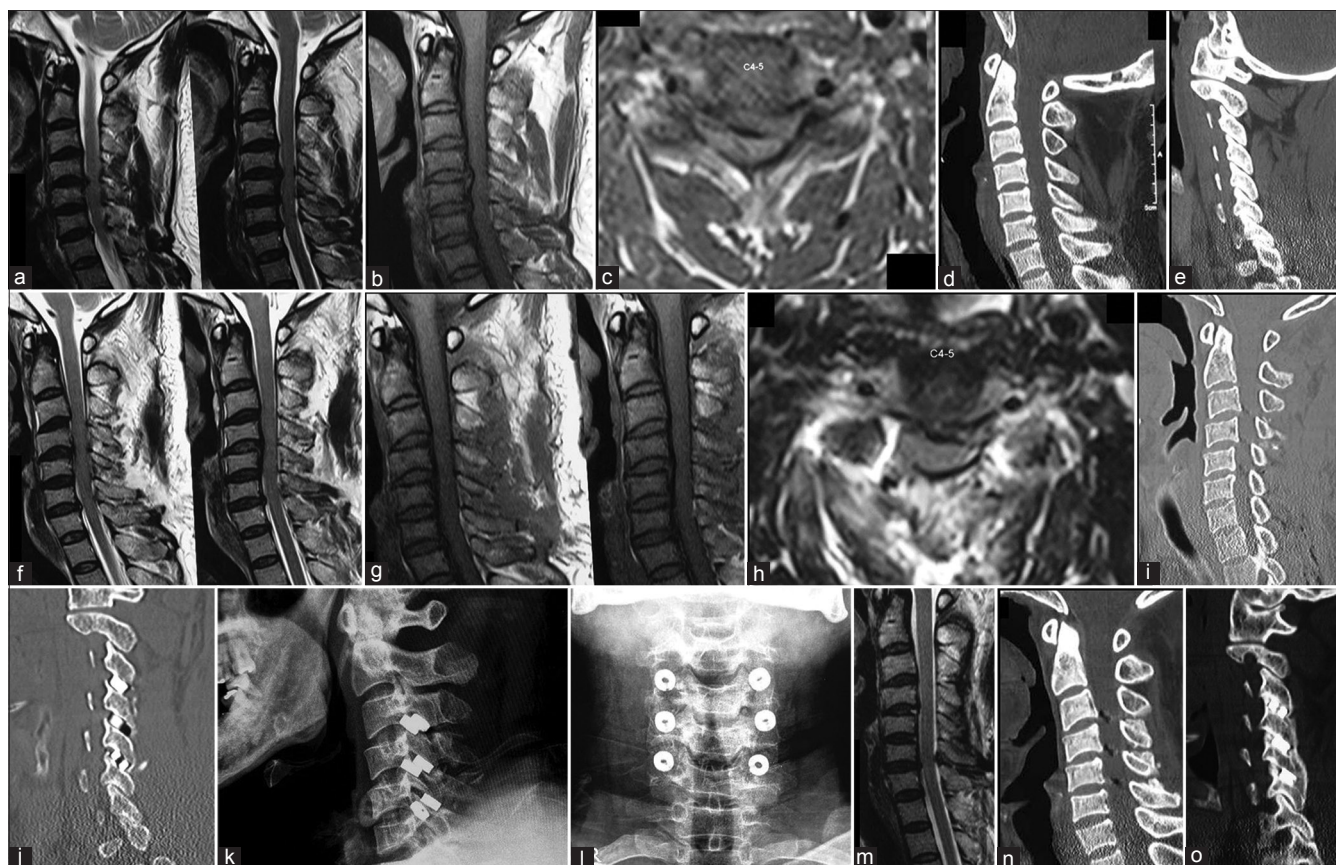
Images of a 45-year-old male patient. (a) Sagittal T2-weighted magnetic resonance imaging showing the C4-5 level disc protrusion. (b) Sagittal T1-weighted magnetic resonance imaging showing the herniated disc and an intact posterior longitudinal ligament. (c) Axial scan showing the herniated disc. (d) Preoperative computed tomography scan - sagittal image. (e) Preoperative computed tomography scan with sagittal cut passing through the facets. (f) Postoperative T2-weighted magnetic resonance imaging showing the restoration of the herniated disc and an increase in the disc space height. (g) T1-weighted magnetic resonance imaging showing the restoration of the disc in the disc space. (h) Axial image showing the reduction in the herniated disc size. (i) Computed tomography scan showing the increase in the height of the disc space. (j) Postoperative scan showing spacers within the C3-C4, C4-C5, and C5-C6 levels. (k) Lateral X-ray showing spacers within the facets. (l) Anteroposterior X-ray showing the spacers. (m) T2-weighted magnetic resonance imaging done 36 months after surgery shows no evidence of recurrence of disc herniation. (n) Sagittal image of computed tomography scan shows the evidence of midline bone fusion between C3 and C6 levels. (o) Sagittal image through the facets showing fusion between C3 and C6 vertebral levels
